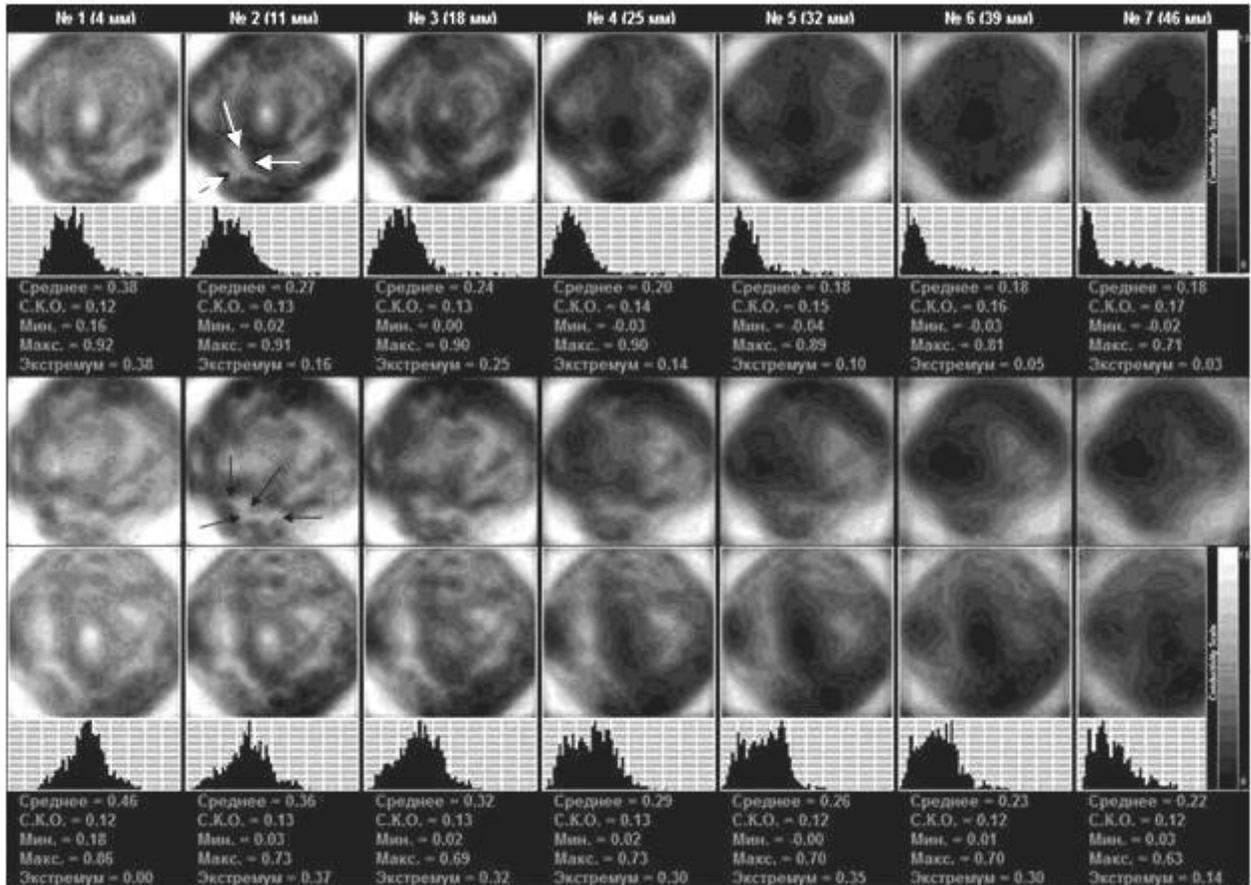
EIM. Top row – left gland. Fibrous type of mammary gland structure. The hyper-impedance contour can be observed around the gland. In the lower segment there is an irregular-shaped iso-impedance formation measuring 27x17 mm with a hyperimpedance contour. The middle row represents the outer segment of the left gland. Lower row – right gland. Fibrous type of mammary gland structure. ULTRASOUND: In the lower segment of the left gland there is observed an inhomogeneous area with irregular blurred contours, measured 23x25x18 mm, with vascularization. There are two lymph nodes 15x8 and 13x8 mm in the axillary crease area..
